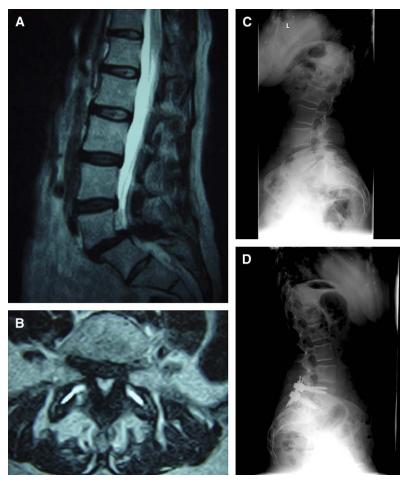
Preoperative sagittal (A) and axial (B) MRI scans of a patient with grade I spondylolisthesis and stenosis, a preoperative lateral radiograph (C), and a postoperative lateral radiograph after MI-TLIF (D).
